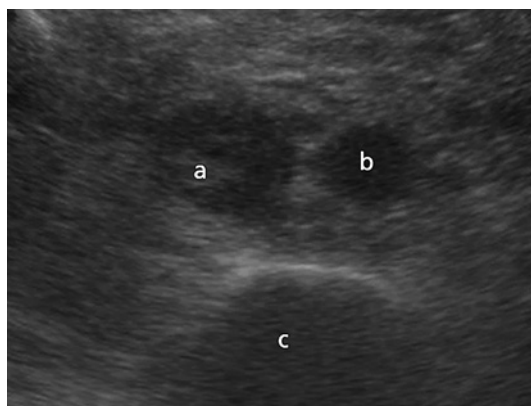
Ultrasound scan of the abdomen showing echogenic thrombus within a dilated non-compressible IVC (A), a normal calibre aorta (B) and a vertebral body (C).
